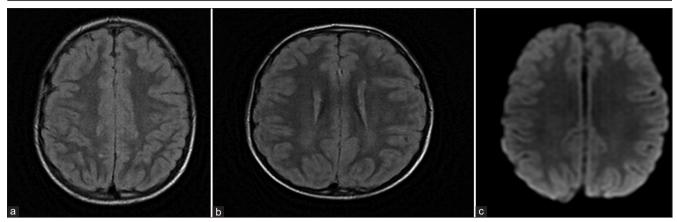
Post-treatment, comparison: almost complete resolution of the high FLAIR signal intensities (a and b) without restriction on the DWI images
